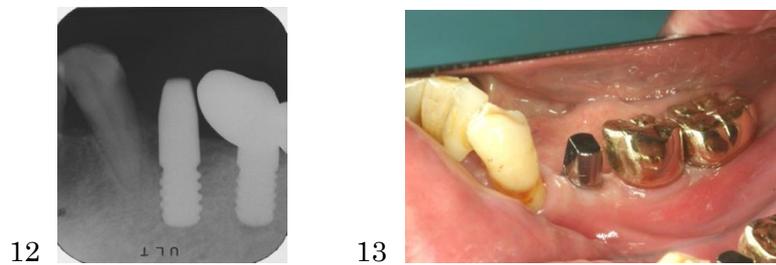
Dental radiograph after the 5MM implant was installed with a delay, onto position No. 28.
